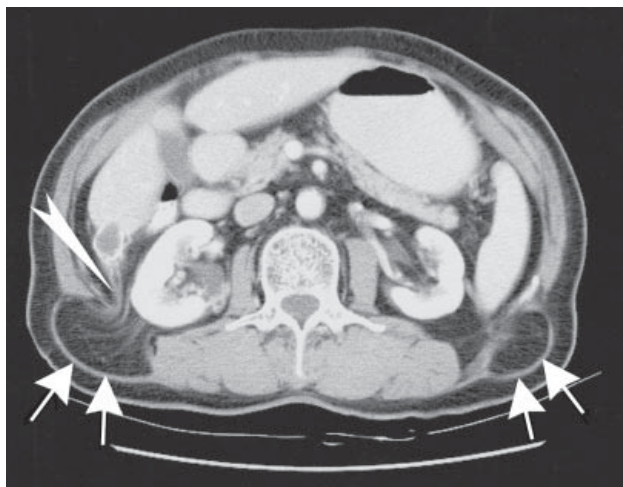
Computed tomography scan at the level of the necks of the lumbar hernias (arrows) showed retroperitoneal fat and stranding passing through the abdominal wall defects. Part of the Gerota's fascia was herniating on the right side (arrows head).
